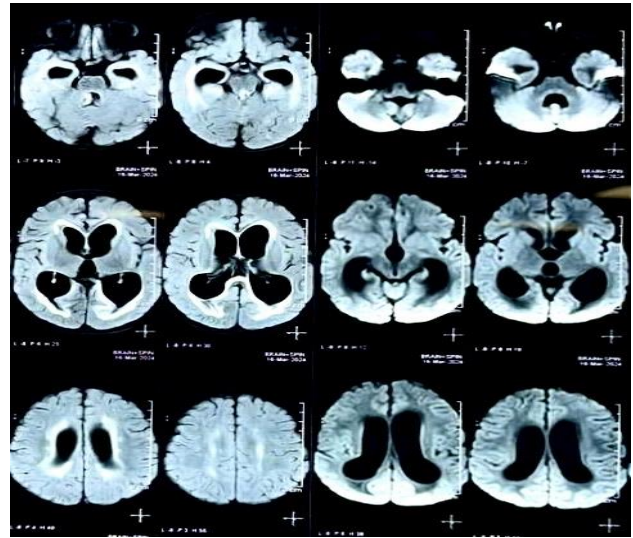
Magnetic resonance imaging of the brain shows bilaterally dilated ventricles.
